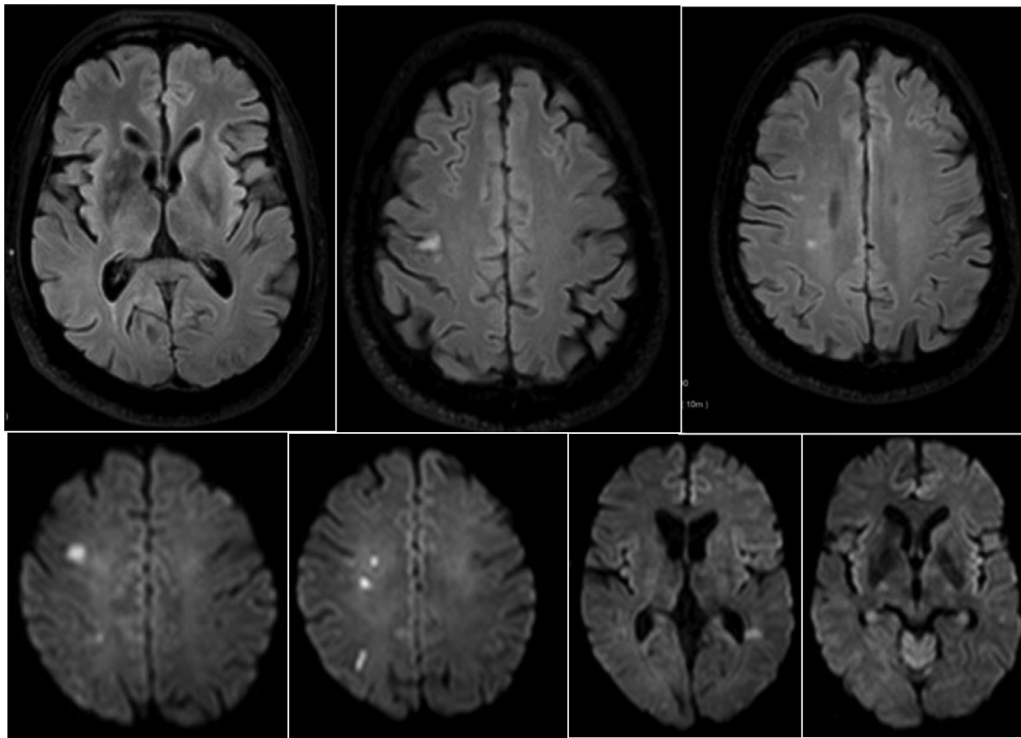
Flair and DWI sequence of brain MRI: demonstrating multiple areas of acute cortical lacunar infarctions.
